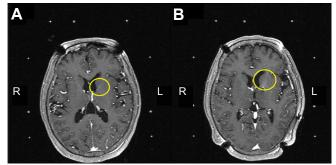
T1-weighted double-dose gadolinium-enhanced brain MRI scans of a 73-year-old female patient treated with levodopa for 8 years, presenting with aggravated whole body dyskinesia.
